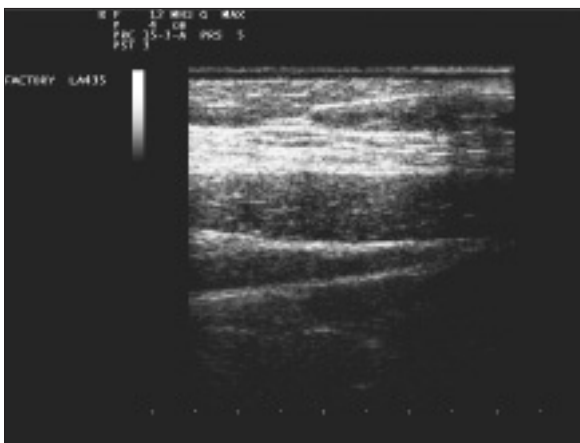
US scan of the subcutaneous abdomen region performed with a 12 MHz linear array transducer shows the normal sonographic pattern of the cutaneous, subcutaneous and muscular planes.
